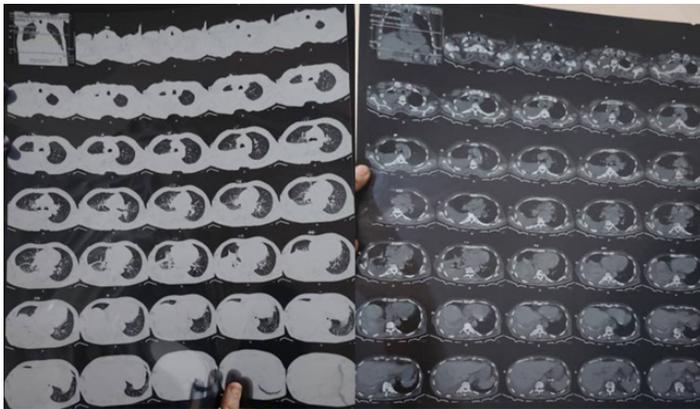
CT chest shown right catheter noted intimately related to right IJV, SVC and Azygos veins passing posteriorly with tip at D8 level right para vertebral piercing the posterior wall at the junction of SVC and Azygos veins. with right high density pleural effusion and cardiomegaly.
